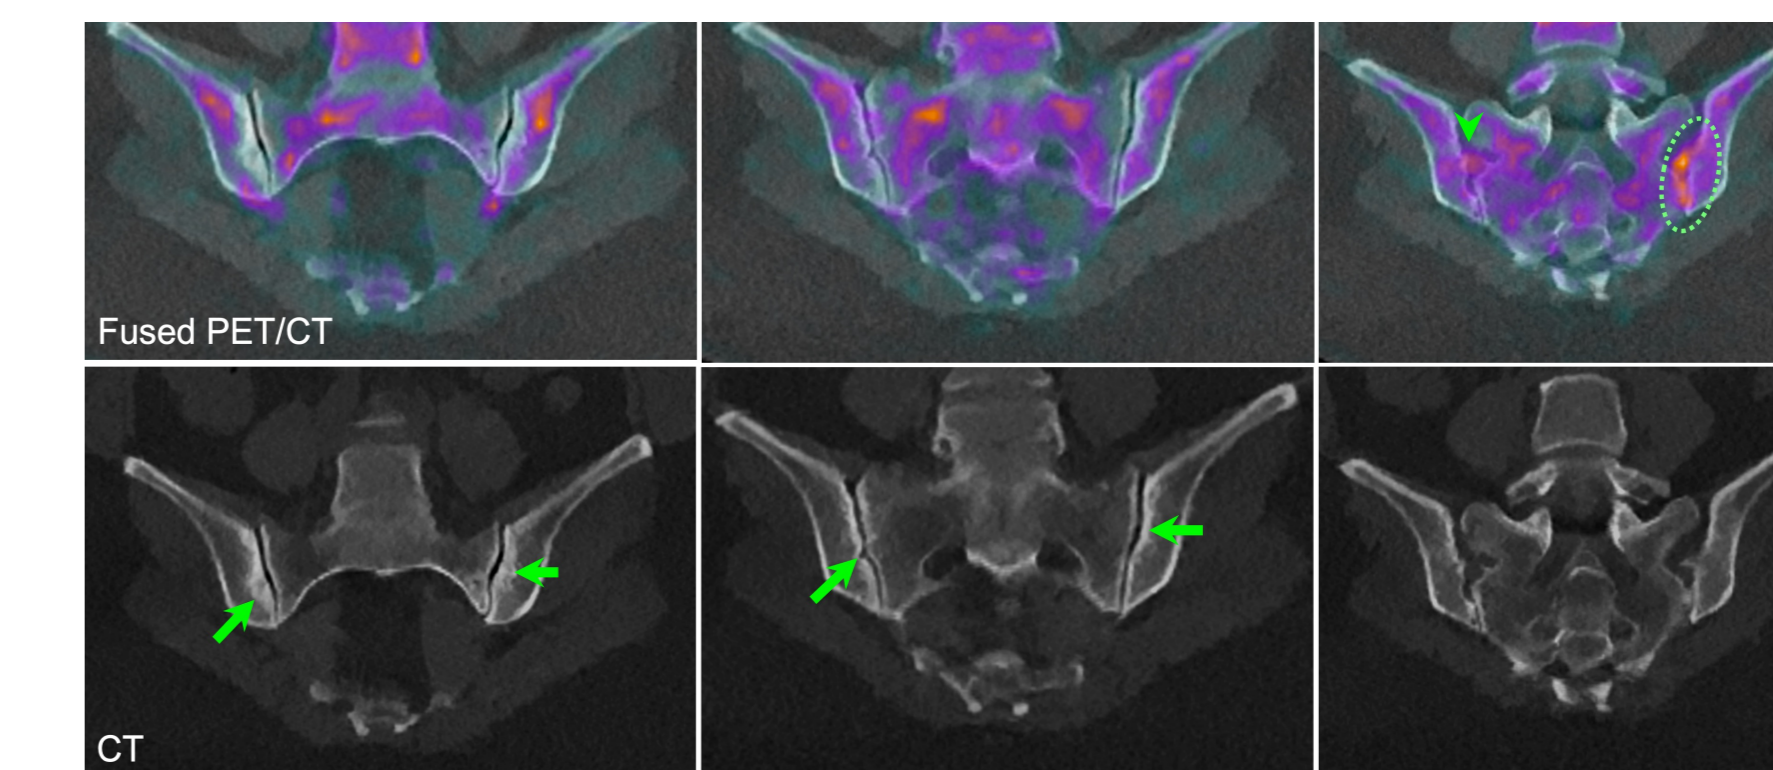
Asymmetric sacroiliac changes. TB-PET/CT of a 36-year-old female participant with PsA demonstrating asymmetrically increased ¹⁸F-FDG on the left side (dashed circle) with minimal uptake on the right side (arrowhead). Coregistered CT images demonstrate rather symmetric SIJ sclerosis, more pronounced on the iliac side of the joints bilaterally (arrows).
